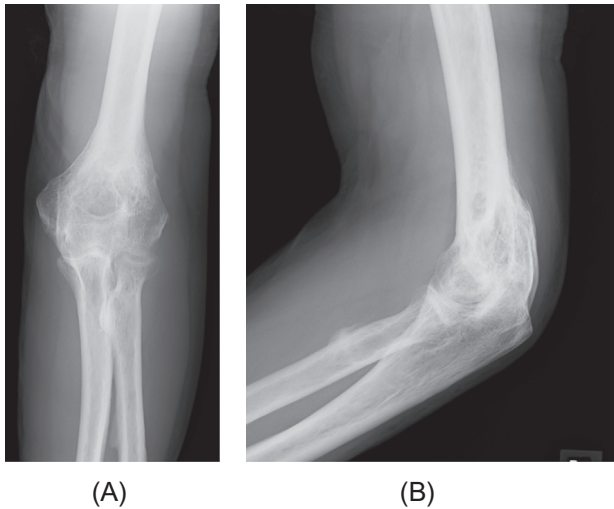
AP (A) and lateral (B) radiographs showing HO bridging the humeroulnar joint at the initial visit.
